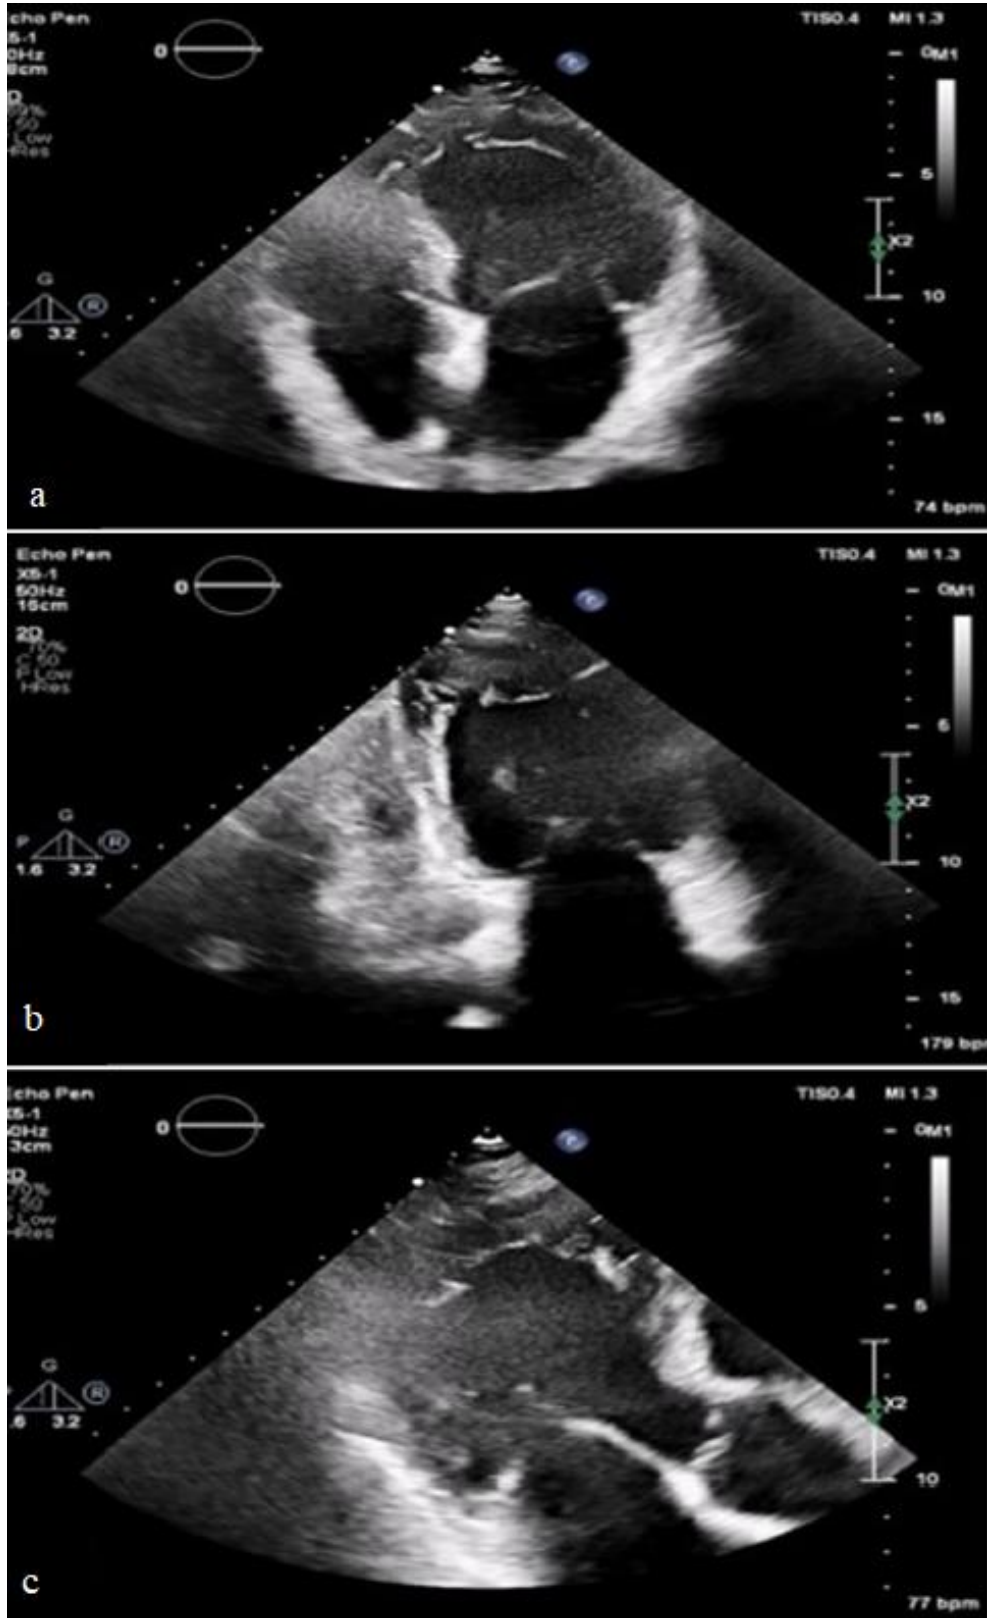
Transthoracic echocardiography (TTE) – baseline assessment; apical views: a) 4-chamber, b) 2-chamber, c) 3-chamber (arrows – increased echogenicity of left ventricle endocardium).
